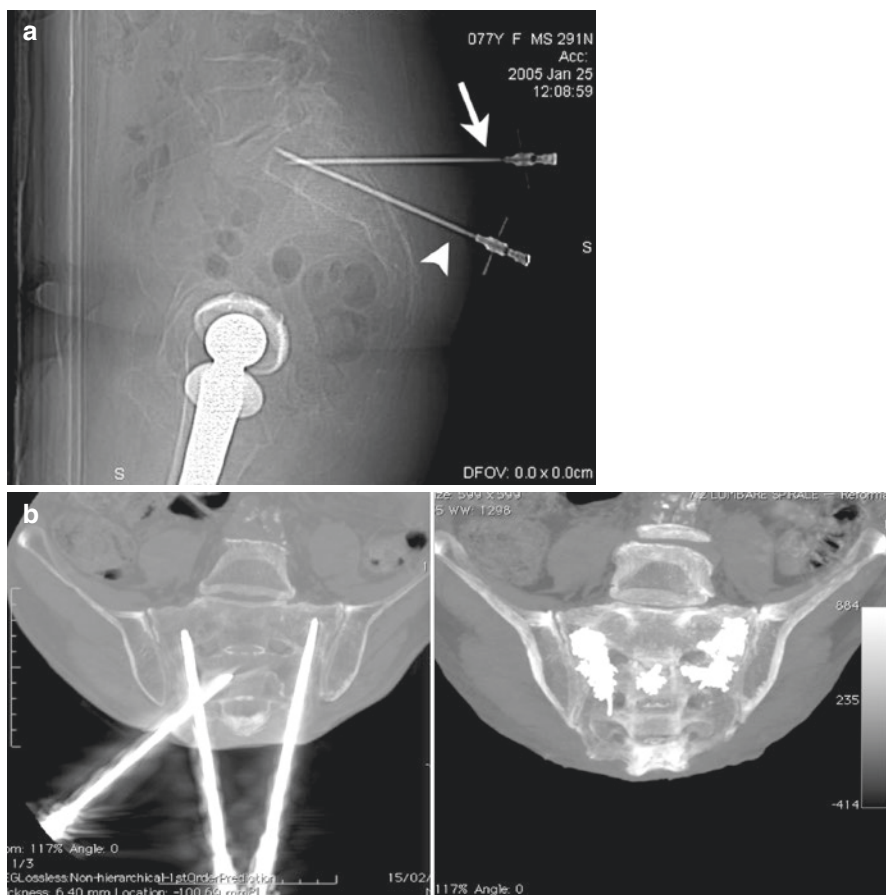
Bilateral symmetric sacral fracture: different needle approaches on X-ray and CT guide. A couple of needles are oriented along the main axis of the sacrum, to fix the body-to-wing fractures, while a direct transversely oriented needle is centered into the body of S2 (a, b left). After PMMA injection, complete sacroplasty of the “H-shaped” fracture is obtained (b right)
